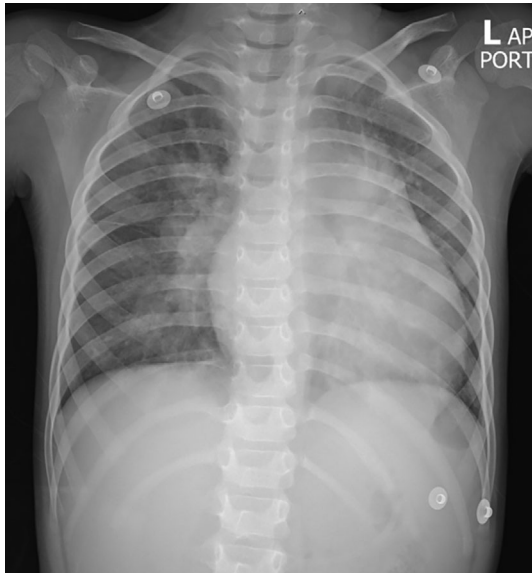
Chest x-ray revealed cardiomegaly with increased pulmonary vasculature and bilateral perihilar opacities with air-bronchogram
